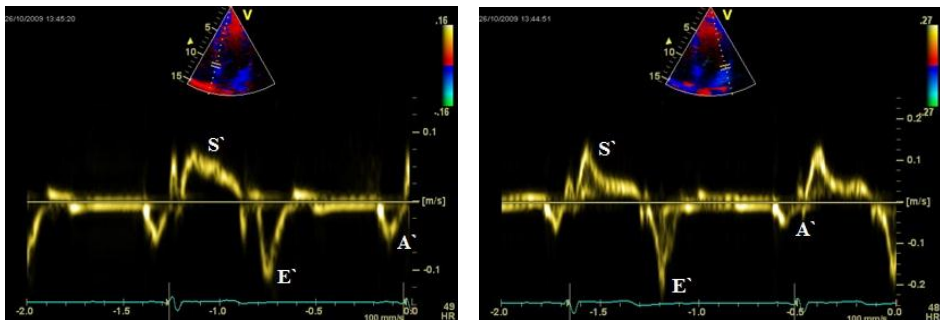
Tissue Doppler imaging from apical 4-chamber view. Normal values for systolic (S'), early diastolic (E') and late diastolic (A') mitral septal (left panel) and lateral (right panel) annular myocardial velocity.
